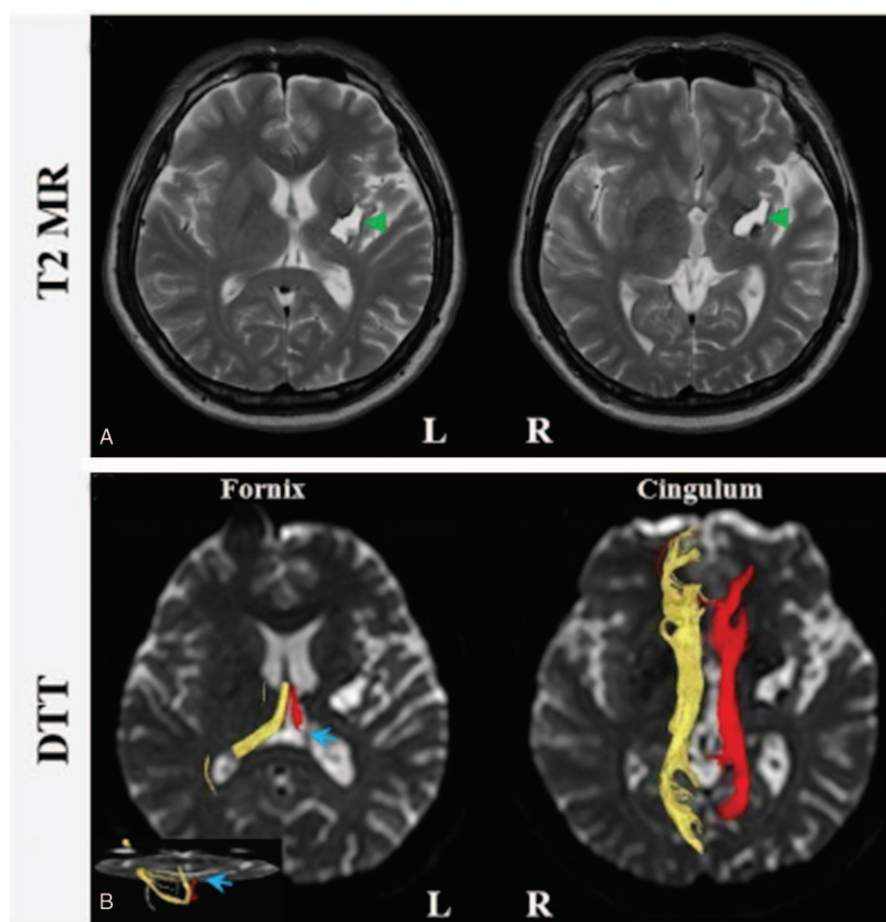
Representative T2-weighted magnetic resonance images and diffusion tensor tractography (DTT) of a 42-year-old man with a putaminal hemorrhage at 55 months after onset in the left hemisphere. The magnetic resonance images reveal a chronic lesion (green arrowheads) in the left putamen (A). DTT images show that the left fornix is discontinued compared with the right fornix (blue arrows). The right fornix and the cingulum at the both sides were well reconstructed (B). L=left hemisphere, R=right hemisphere.
